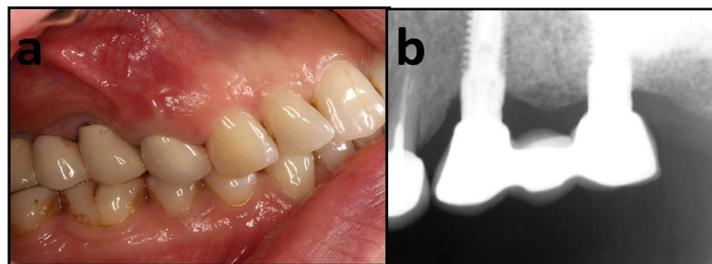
A. Clinical photograph taken 18 months after the surgery. B. Periapical radiograph 18 months after the surgery.
